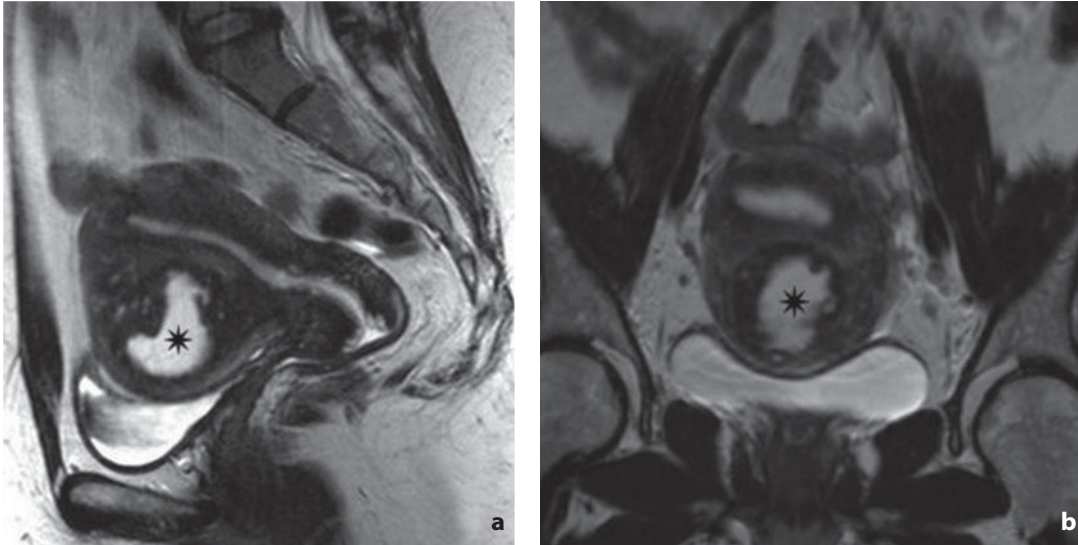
Magnetic resonance. Leiomyoma. Sagittal (a) and coronal (b) T2-weighted images. Lesion with area of cystic degeneration (asterisk)
